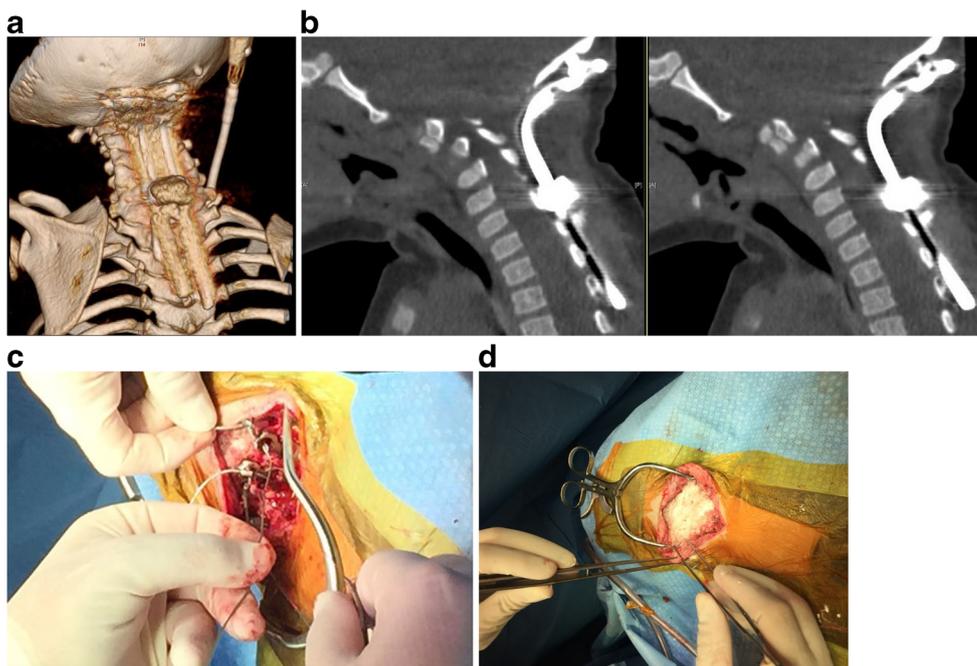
a 3-D reconstruction CT scan of cervical spine with the fusion of bilateral rib autografts. b CT scan of cervical spine revealing bilateral occipital screws pull out. c, d Intraoperative images revealing placement of bilateral suboccipital wires around the top holes of the occipital plates followed by the use of HydroSet bone cement on top of the construct
